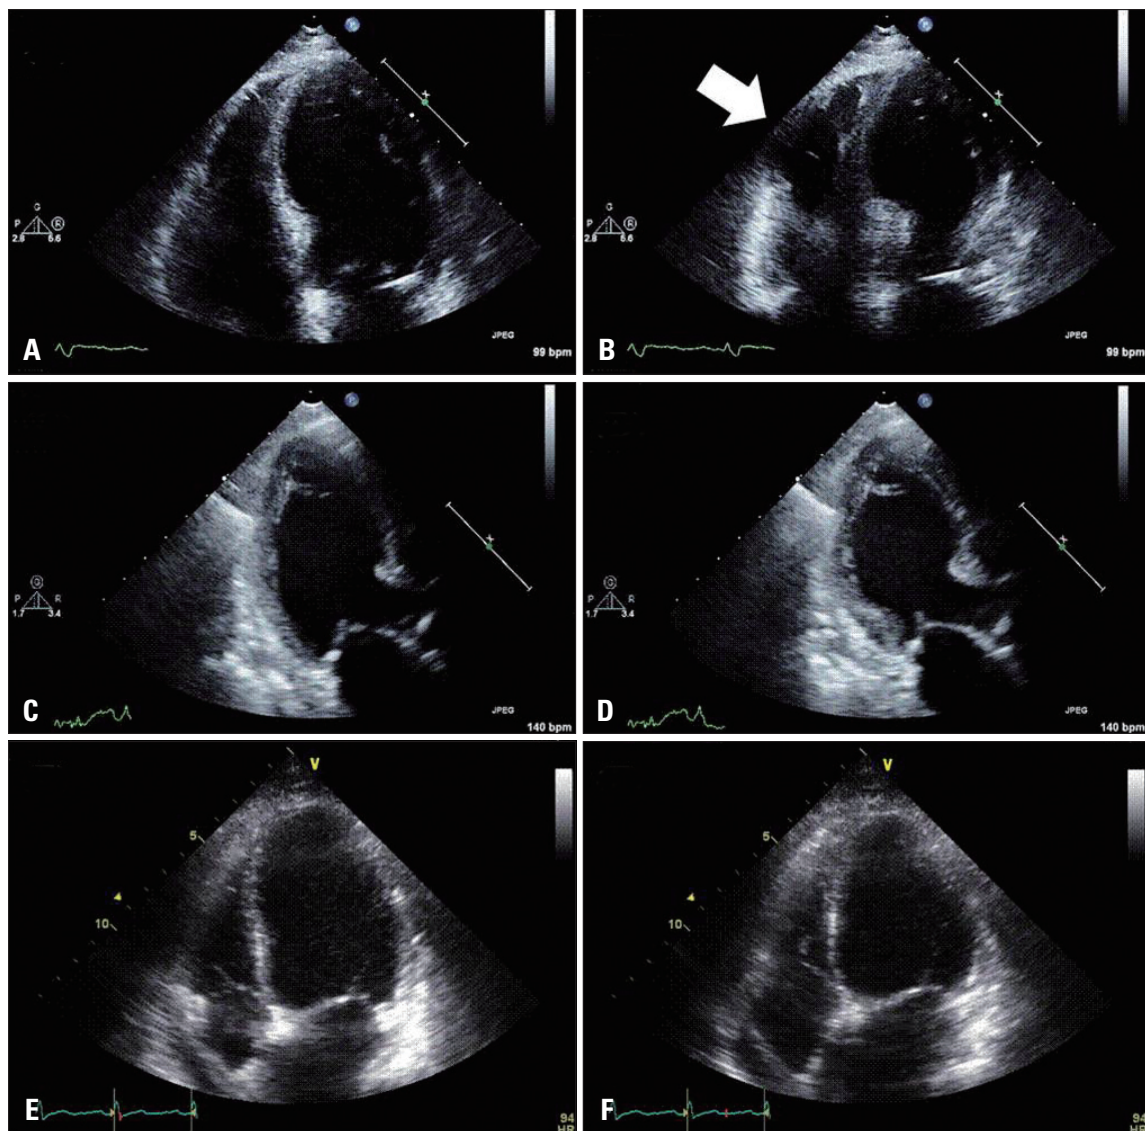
Three cases of stress-induced cardiomyopathy (SCM). Apical four-chamber views in diastole (A) and in systole (B) of a 75-year-old woman with apical ballooning SCM subtype and right ventricular (RV) involvement. Note ballooning of the mid to apical segments and hyperkinesis of the base of the left ventricle (LV). The arrow indicates concomitant ballooning of the RV apex during systole. Apical long-axis views in diastole (C) and in systole (D) of an 82-year-old woman with non-apical ballooning subtype of SCM involving midventricle. Apical four-chamber views in diastole (E) and in systole (F) of a 54-year-old man with non-apical ballooning subtype of SCM involving basal segments. Note ballooning of the LV base during systole.
